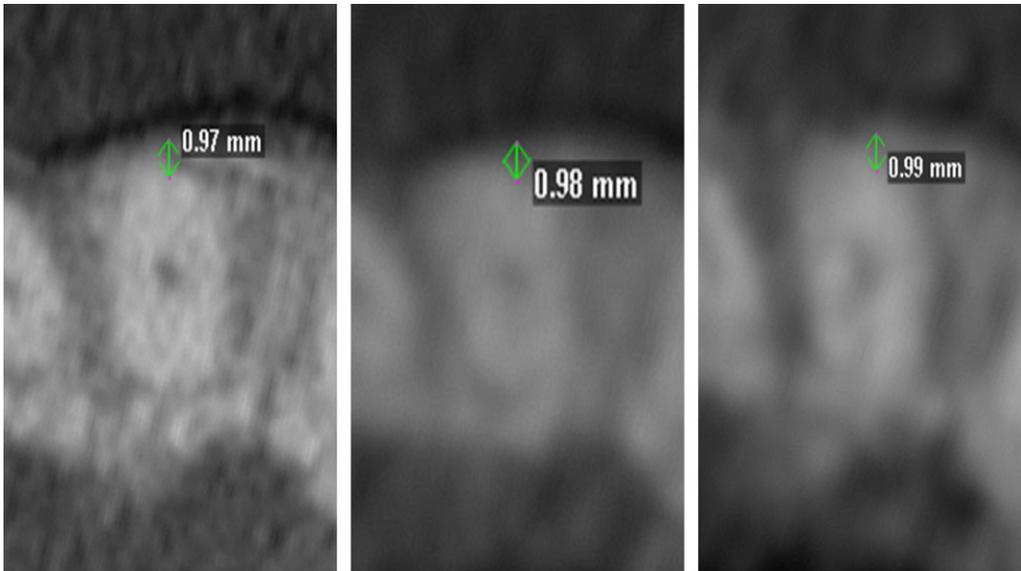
Example of buccal bone thickness (BBT) measurement from cone beam computed tomography (CBCT) sections using long scan (left), default scan (9; center), and short scan (right) CBCT acquisition settings.
